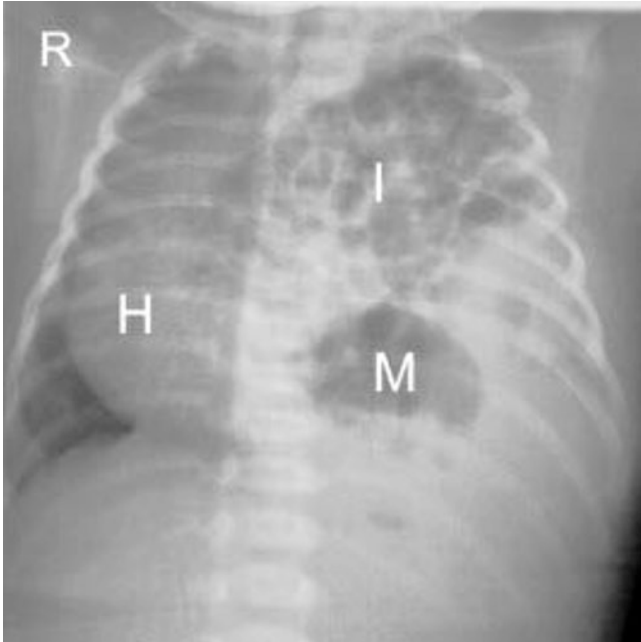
Diaphragmatic hernia II. Postpartum X-ray confirms gastric and bowel punching above the diaphragm
